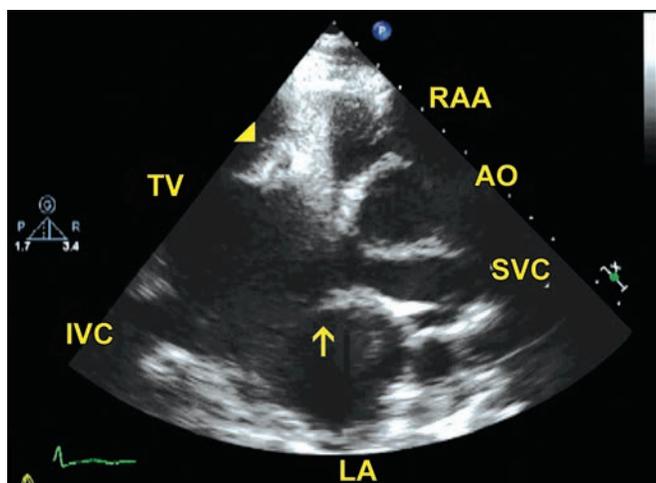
Right parasternal examination. Arrowhead points to right coronary artery and arrow to interatrial septum.
